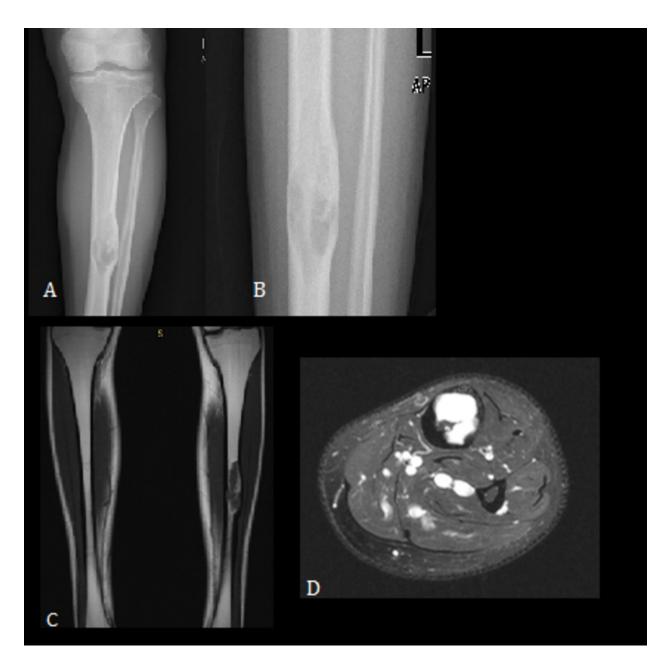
Solitary bone cyst. Anterior-posterior (A) and lateral radiographs (B) reveal bone expansion with cortical thinning adjacent to a well-defined lytic lesion located in the middle third of the left tibia. Coronal T1 weighted image (C) axial T2 FS weighted image (B) show a intramedullary lesion located in the middle third of the left tibia with bone expansion and thinning of the adjacent cortical without disruption. This lesion has multiloculated areas with low signal intensity on T1 and high signal intensity on T2 weighted images.C
